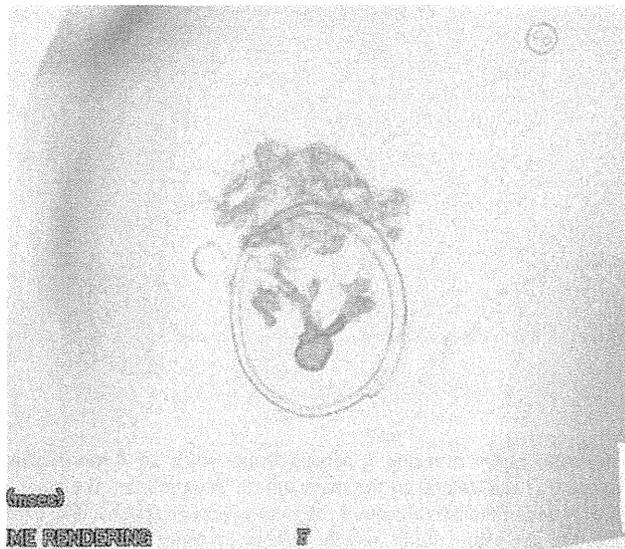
Reconstructed 3D CT image. Intraductal extension continuous from the index cancer
